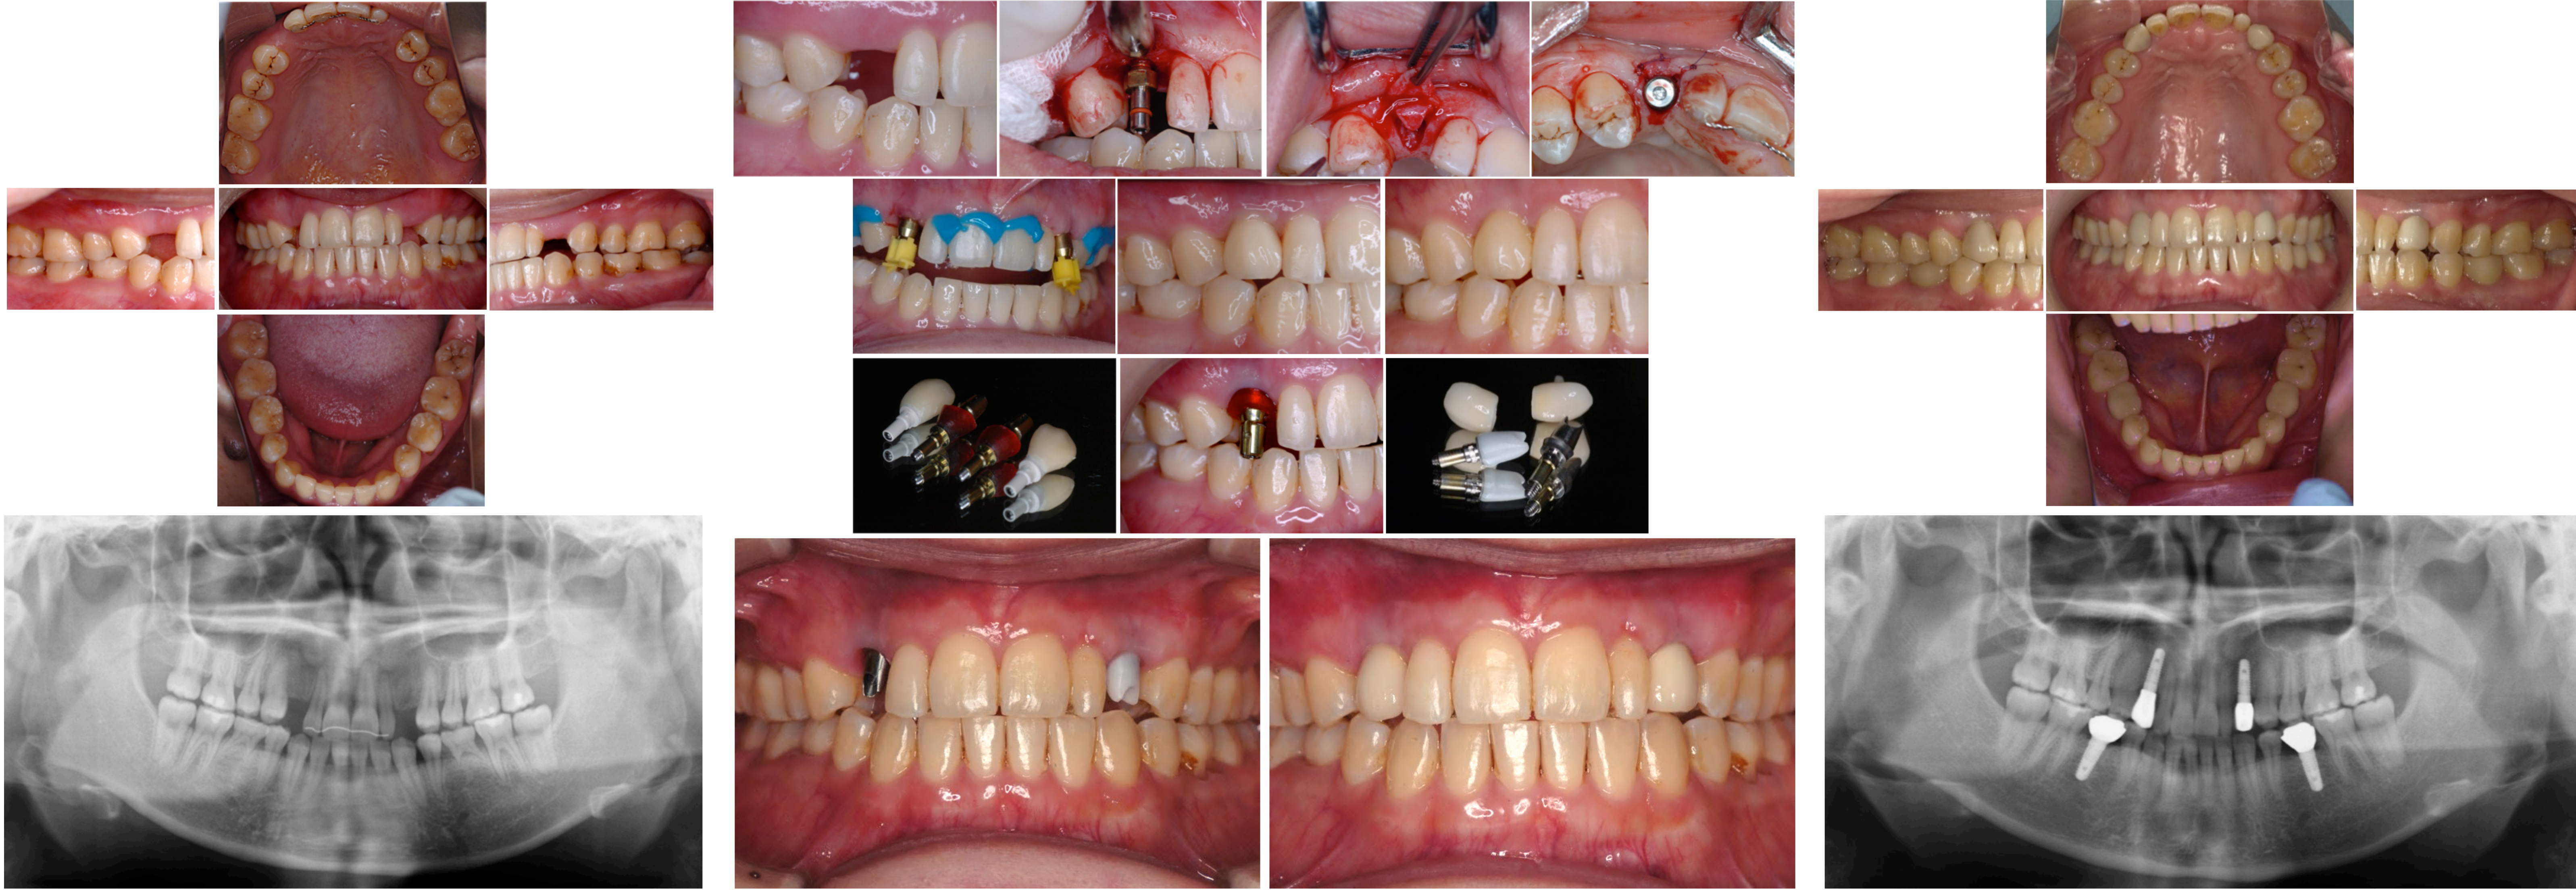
First visit observations and preoperative panoramic radiograph
